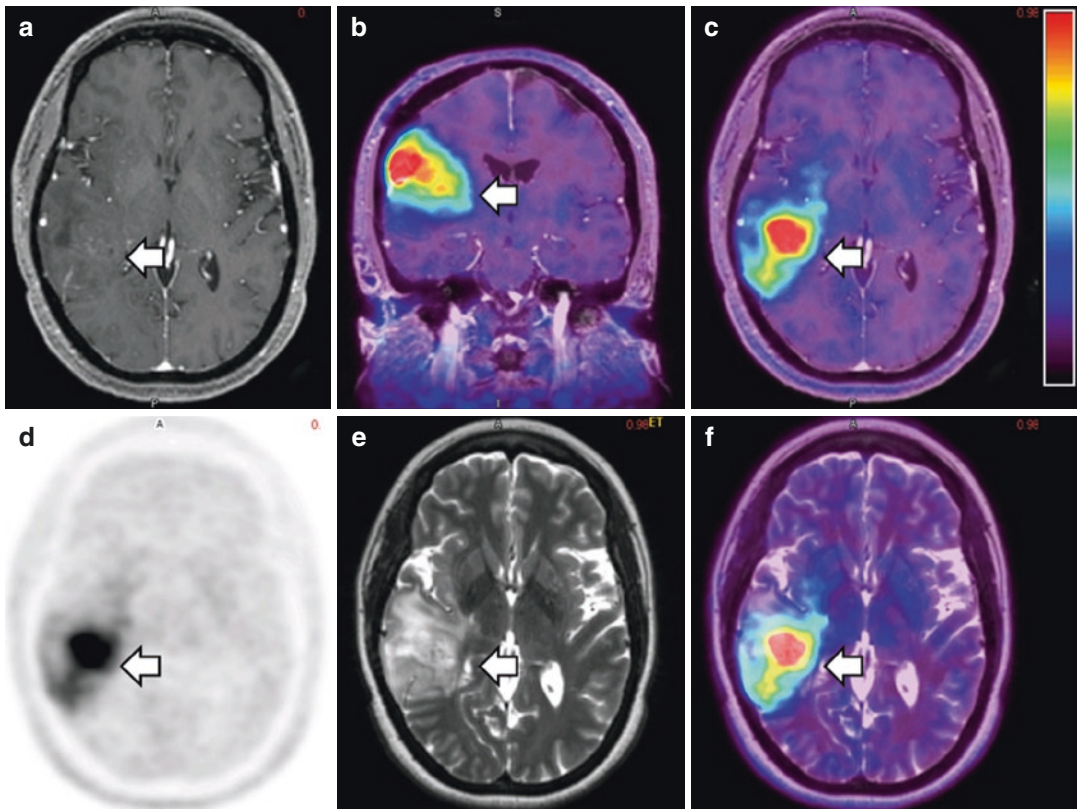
Selected images from an [^{18}F]FDOPA-PET/MRI study performed in a patient with a high-grade glioma. The tumor is indicated with *white arrows*. The axial T1-weighted post-contrast MR image (a) shows minimal contrast enhancement in this region of the tumor, while the [^{18}F]FDOPA-PET image (d) shows increased activity
